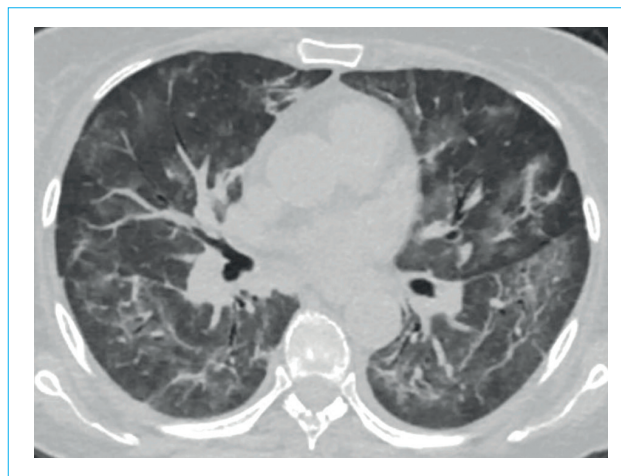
CT-scan of the chest. Polymorphic areas of «ground glass opacity» and reticular changes with indistinct contours in both lungs, with predominantly central distribution. The cumulative lesion volume is 26–50 % on both sides
